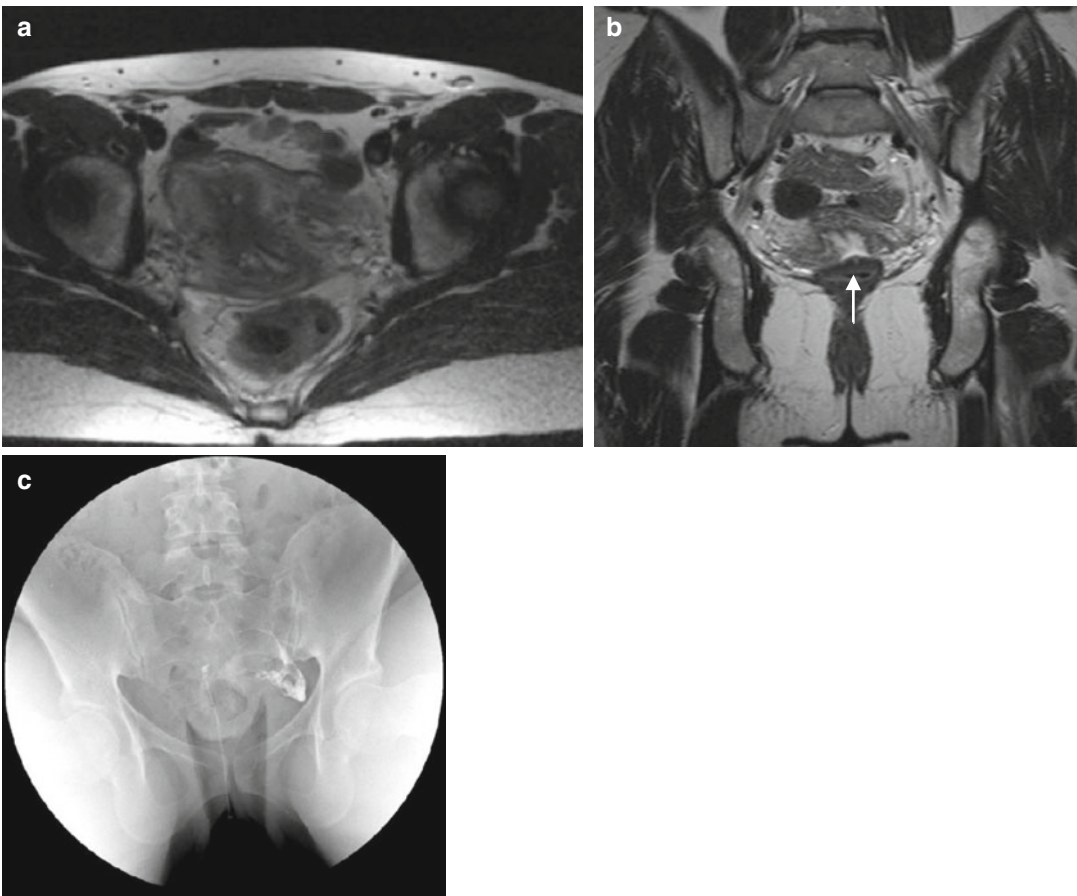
Partial bicornuate uterus (IV b). Fast spin-echo T2-weighted images on axial (TR/TE 4070/94) (a) and coronal plane (TR/TE 3300/108) (b) show large notch between two separate uterine horns and the communication with a solitary cervix (*arrow*). Hysterosalpingography (HSG) image of the same patients (c) shows normal opacization only of the left horn
